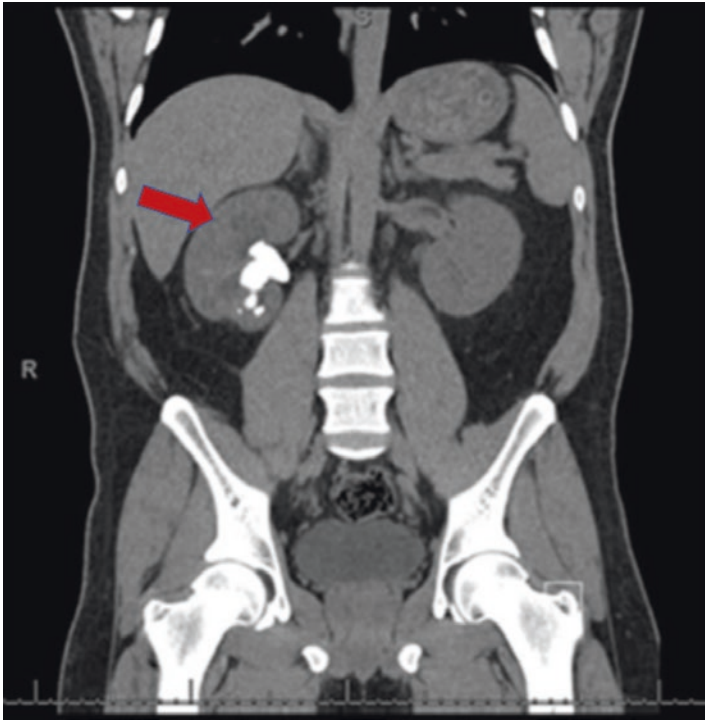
Non-contrast CT showing right-sided staghorn stone associated with hydronephrosis (indicated with red arrow). (Courtesy of University of Iowa, Department of Urology)
